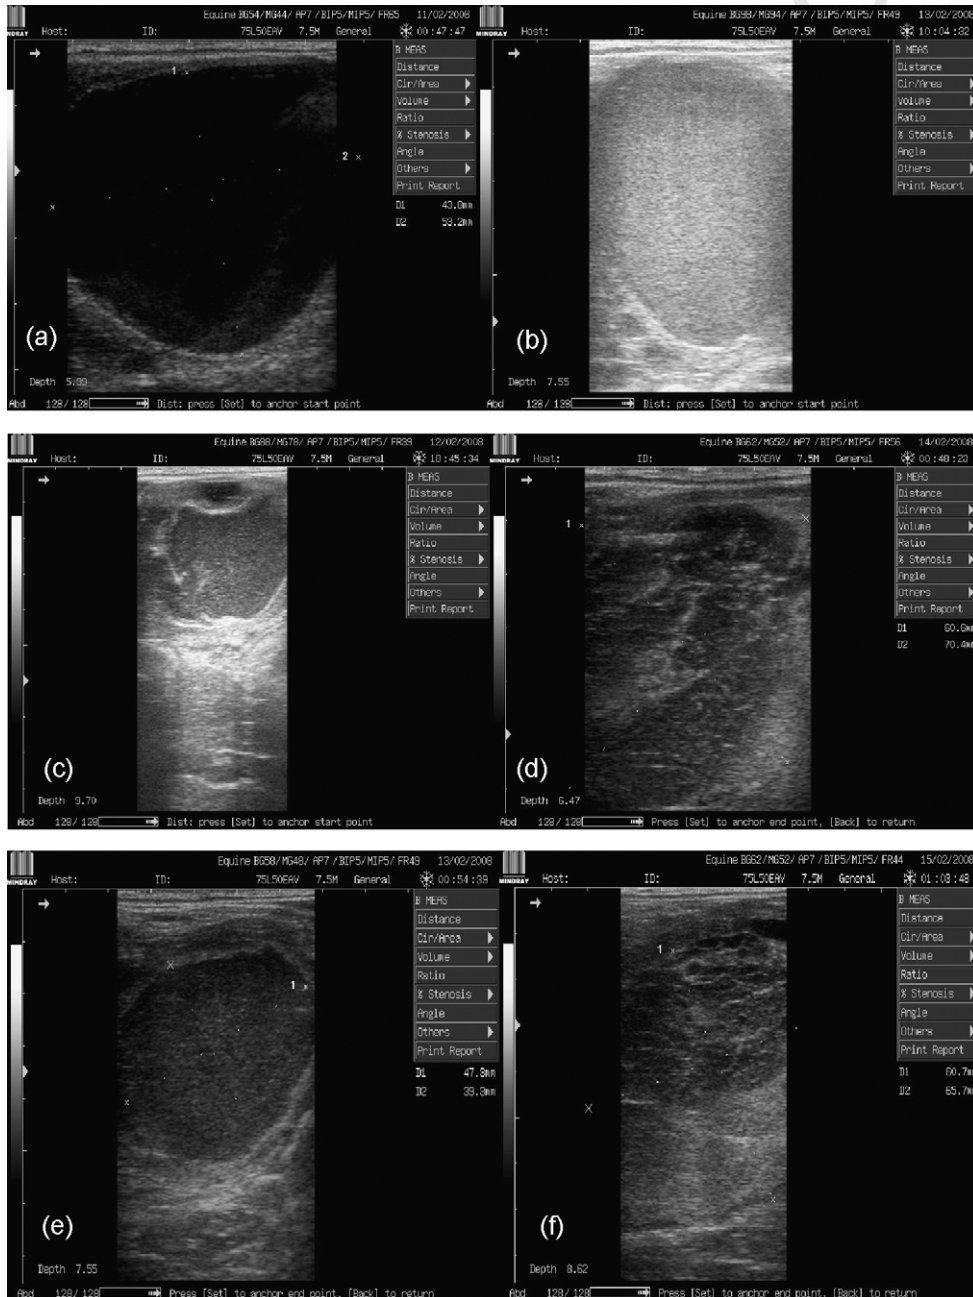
Chronologic order of sonogram series of (A) a preovulatory follicle (a) that hemorrhaged and subsequently luteinized without loss of follicular fluid. (B, C) Follicle fills with blood (hyperechoic specks) and follicular wall thickens and becomes hyperechoic. (D) Increase in number of hyperchoic specks as a result of further hemorrhage. (E, F) Organized follicular contents and luteal tissue become more apparent (lower part of pictures), and the overall diameter of the unruptured follicle increases to more than 60 mm.
